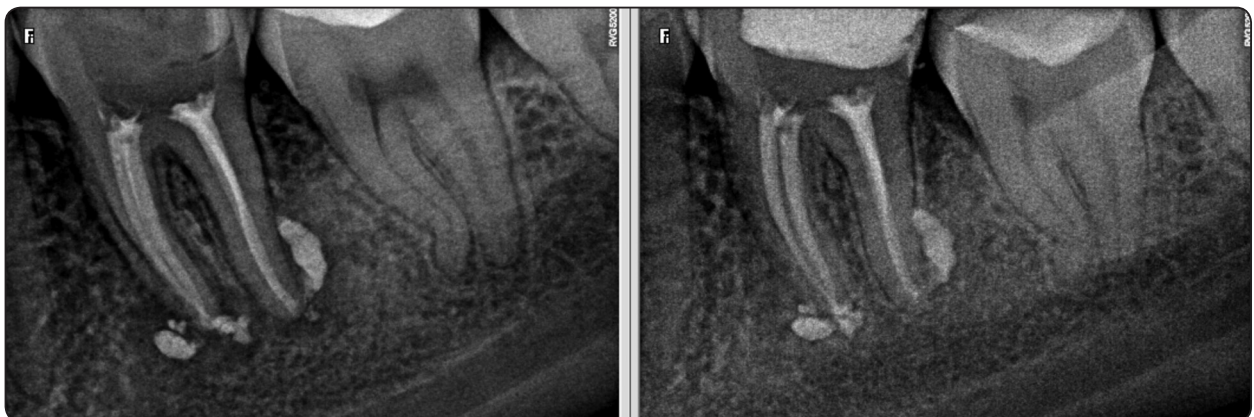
Immediate post-obturation (Lt.) and one-year recall radiograph (Rt.) for cases with extruded TotalFill. Notice the slow rate of extruded sealer resorption and the excellent periradicular healing despite the presence of huge amount of extruded sealer.
